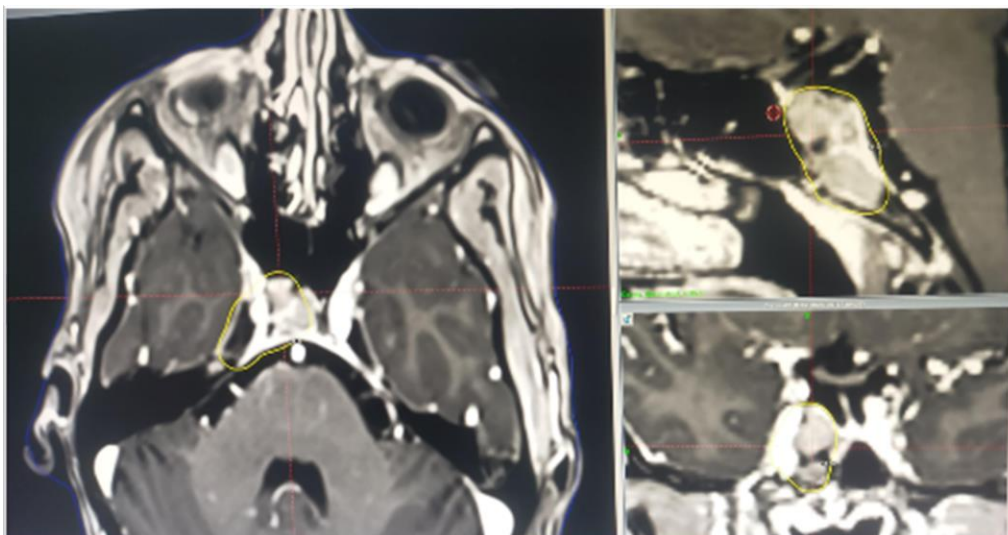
MRI of the brain obtained prior to GKRS: appearance suggestive of schwannoma of the right abducens nerve (measuring 28x26x22) and invading the right abducens nerve and the clivus anteriorly
